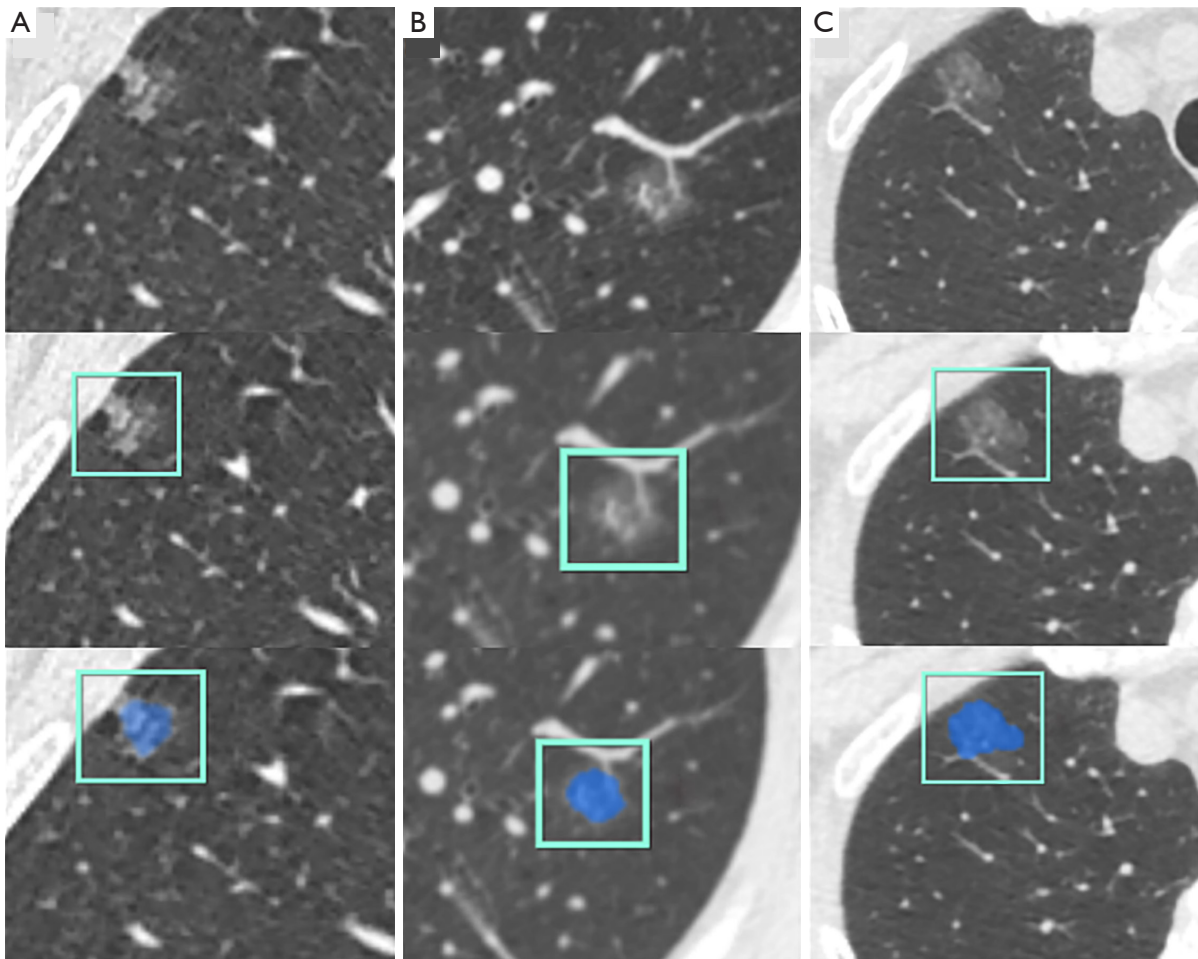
CT images of malignant GGNs which were similar in size but significantly different in mass. An artificial intelligence-assisted diagnosis system was used to automatically recognize and segment the GGNs from CT images and subsequently measure the nodule mass. (A) A 59-year-old woman with AIS. A transverse thin-section CT image showed an irregular and ill-defined PSN located in the right upper lobe with a size of 11 mm × 10 mm and a mass of 120.19 mg. (B) A 70-year-old man with MIA. A transverse thin-section CT image showed a round and ill-defined PSN located in the left upper lobe with a size of 11 mm × 11 mm and a mass of 295.11 mg. (C) A 59-year-old woman with IAC. A transverse thin-section CT image showed an irregular and ill-defined pGGN located in the right upper lobe with a size of 11 mm × 10 mm and a mass of 629.55 mg. CT, computed tomography; GGN, ground-glass nodule; AIS, adenocarcinoma in situ; PSN, part-solid nodule; MIA, minimally invasive adenocarcinoma; IAC, invasive adenocarcinoma; pGGN, pure ground-glass nodule.
